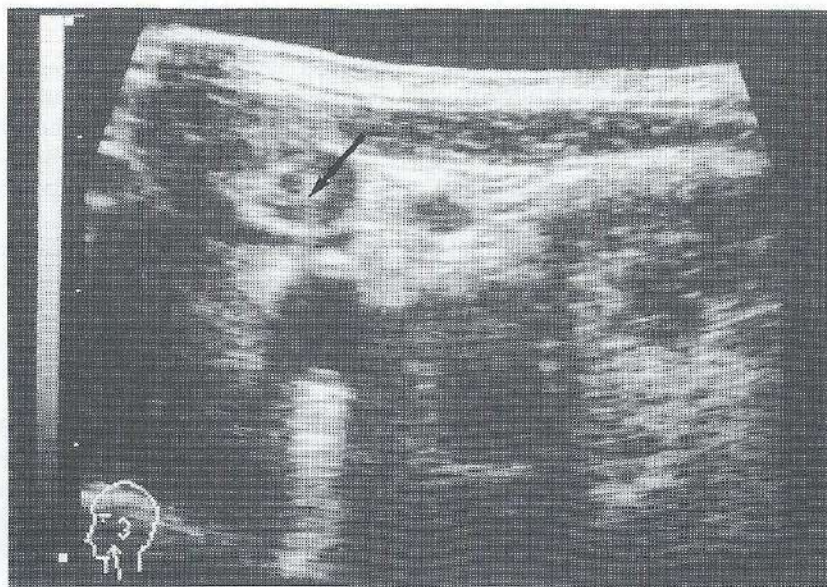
Ultrasound image of a lymph node metastasis during ultrasound-guided fine needle aspiration. The tip of the needle is depicted as a hyperechogenic spot marked by the arrow. For this image a 10 MHz sector-type probe with a built-in water path was used to obtain an optimal graphical representation.
